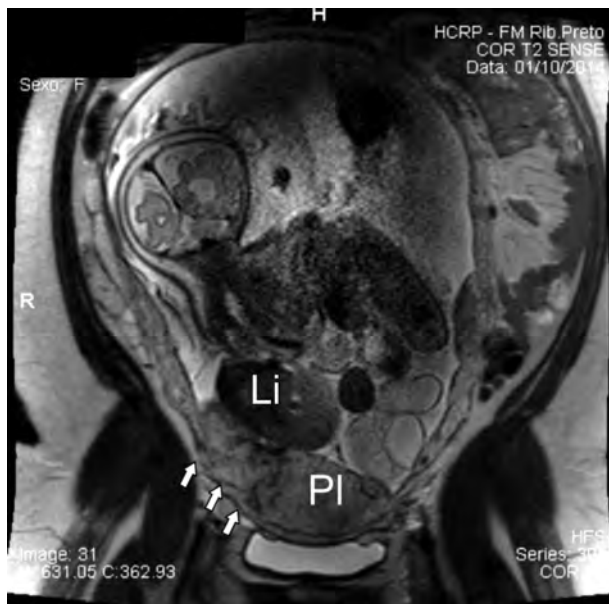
Fetal MRI image showing severe kyphoscoliosis, liver and intestinal loops out of the abdominal cavity and placenta previa with irregular boundaries with the underlying myometrium (arrows). Abbreviations: PL, placenta; Li, liver.
